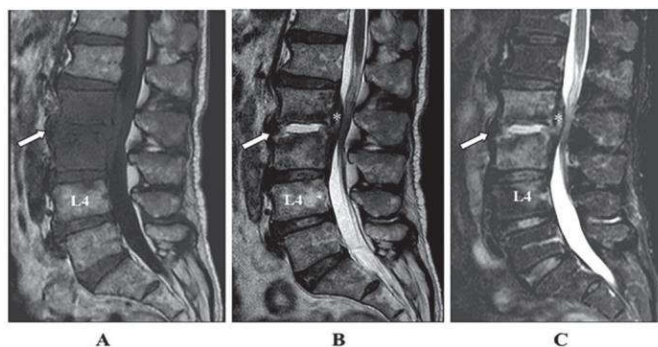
Magnetic resonance imaging (MRI) findings of Staphylococcus aureus pyogenic spondylitis in 77-year-old man. (A) T1 weighted sagittal image demonstrates hypointense signal in L2-3 vertebral bodies and the disc space (arrow). (B) T2 weighted sagittal image shows hyperintense signal in L2-3 disc space (arrow) with epidural mass (*). (C) The short T1 inversion recovery (STIR) sagittal image shows hyperintense signal in L2-3 vertebral bodies and disc space (arrow) with epidural mass (*)¹⁴
